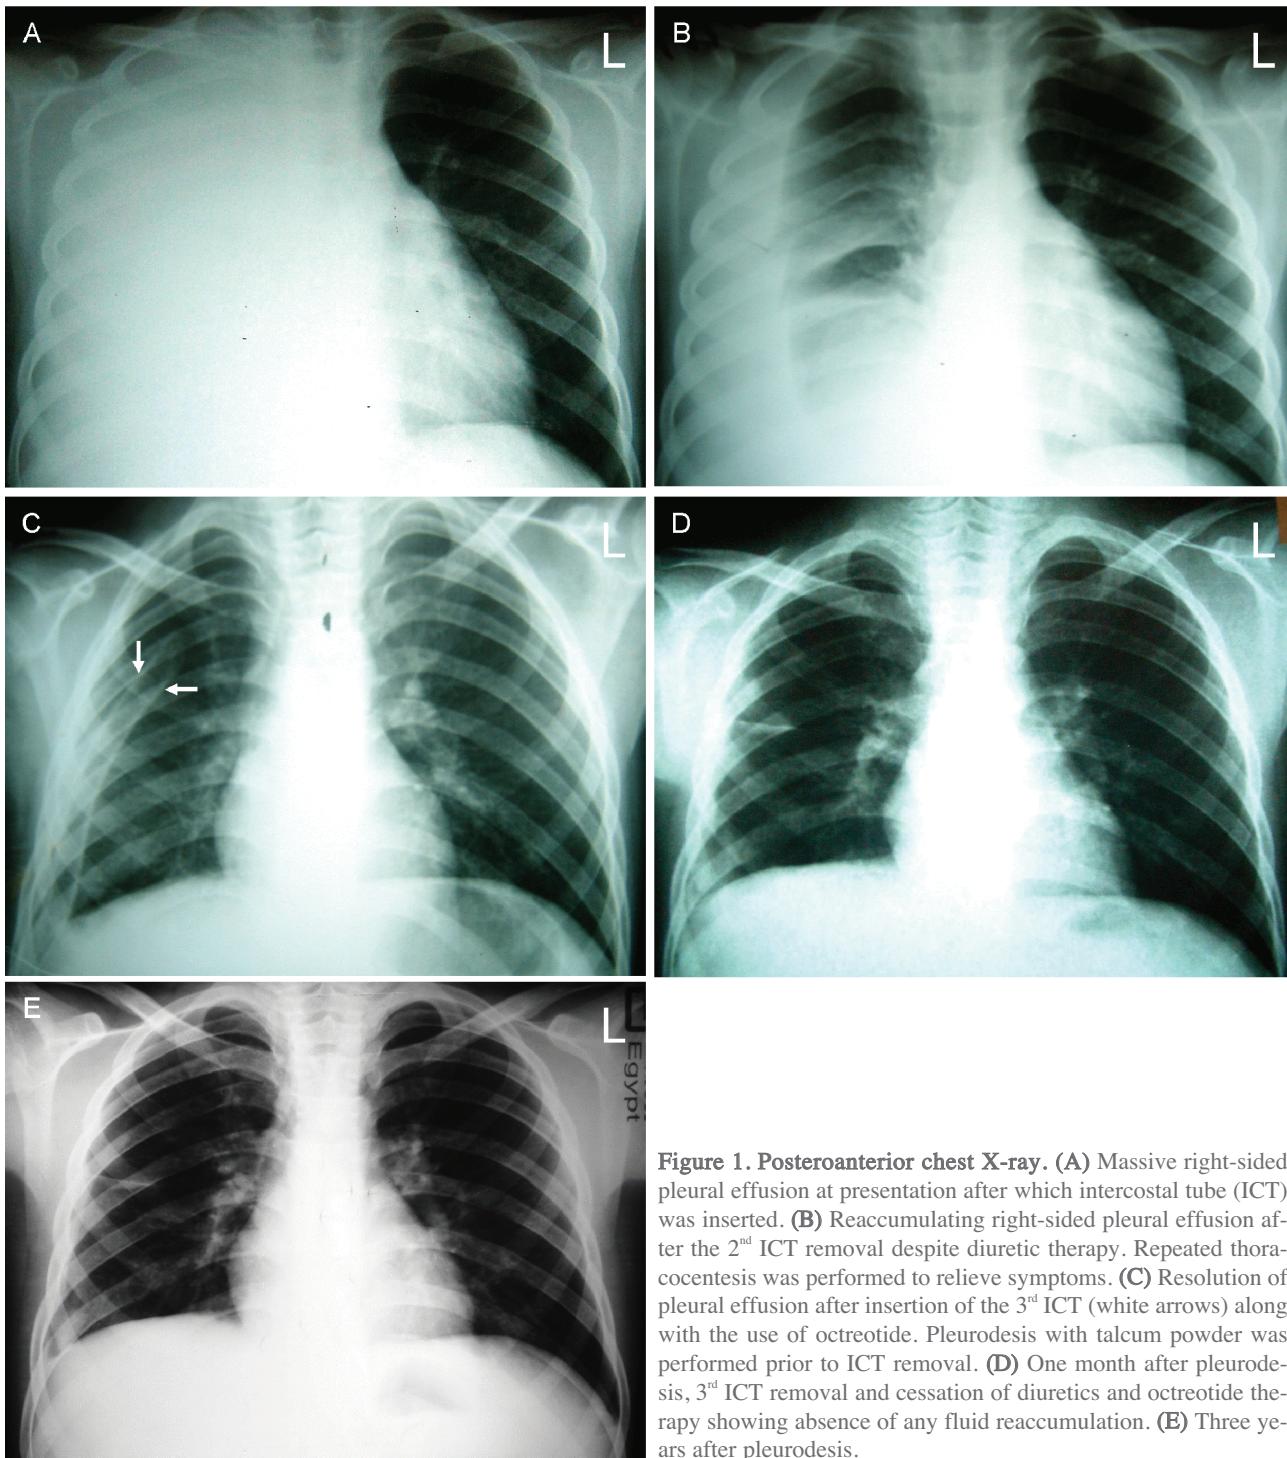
Posteroanterior chest X-ray. (A) Massive right-sided pleural effusion at presentation after which intercostal tube (ICT) was inserted. (B) Reaccumulating right-sided pleural effusion after the 2nd ICT removal despite diuretic therapy. Repeated thoracocentesis was performed to relieve symptoms. (C) Resolution of pleural effusion after insertion of the 3rd ICT (white arrows) along with the use of octreotide. Pleurodesis with talcum powder was performed prior to ICT removal. (D) One month after pleurodesis, 3rd ICT removal and cessation of diuretics and octreotide therapy showing absence of any fluid reaccumulation. (E) Three years after pleurodesis.
